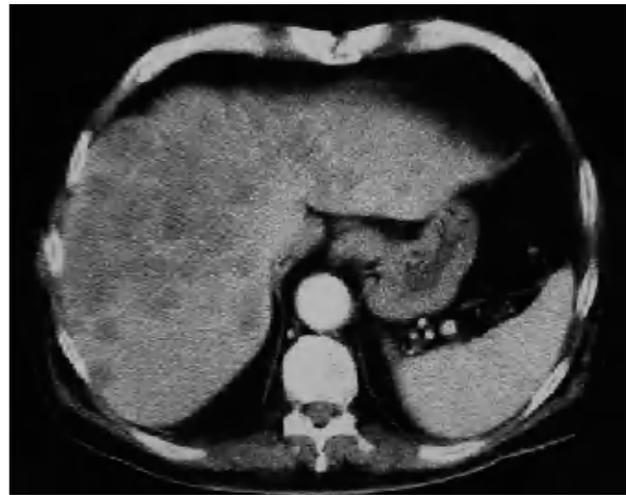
Computed tomography image of the abdomen showing extensive metastases to the liver.
